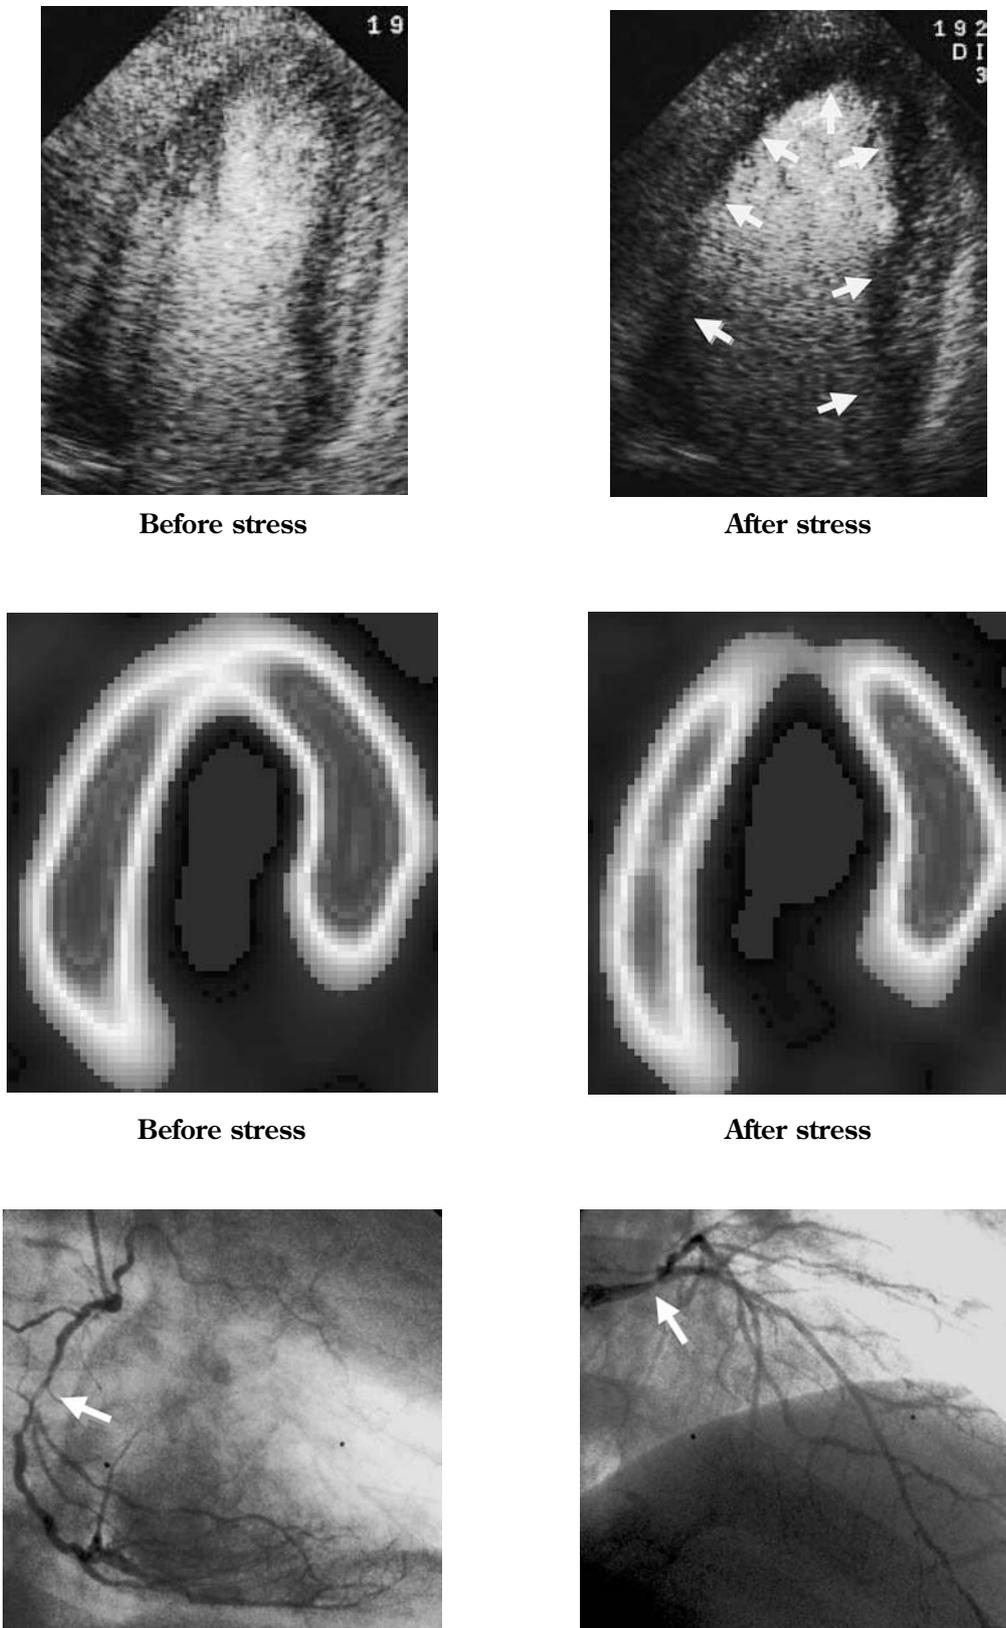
Dipyridamole stress MCE using continuous intravenous infusion of PESDA shows multiple perfusion defects (arrows) in a patient with left main and right coronary artery stenosis. Note the simultaneously performed TC99m sestamibi SPECT images.
